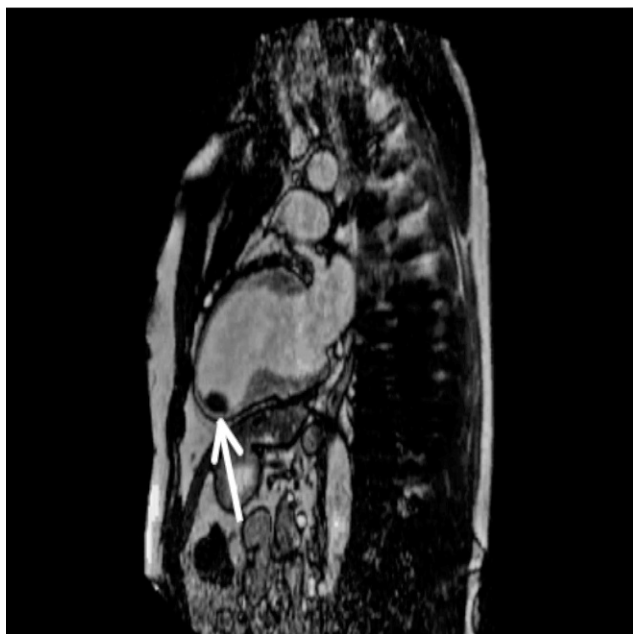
Case: 68-year-old male post left anterior descending infarct. Cardiac magnetic resonance imaging: Cine images, steady state free precession. Diagnosis: Akinesis and thinning of the mid-apical anterior wall and apical inferior wall and apical thrombus (arrow).
